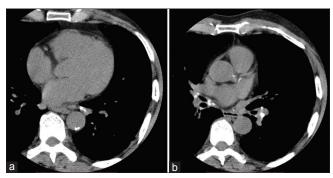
(a and b) Axial computed tomography images show eccentric calcified plaques in proximal right coronary and left anterior descending artery which that a score of 120.13
